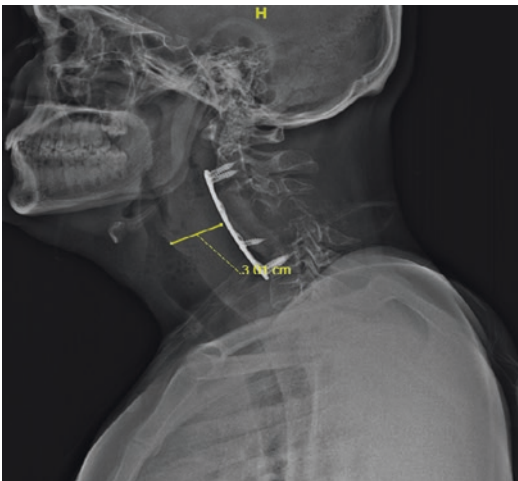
STN lateral X-ray reveals retropharyngeal abscess (35 years male patient underwent corpectomy and C2-C6 fixation for Chordoma 2 years ago)
